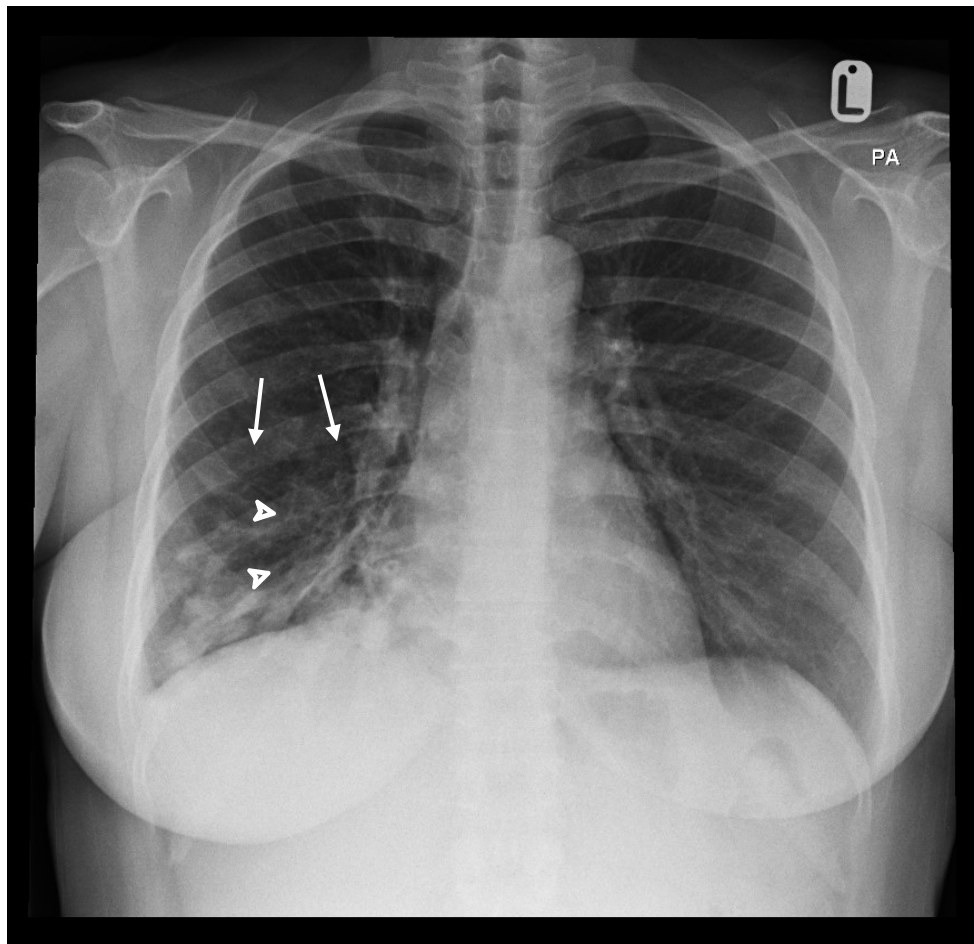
Frontal chest radiograph shows air space opacities at right middle and lower zones with obliteration of right cardiac border in keeping with consolidation. The right transverse fissure is retracted inferiorly (arrow) suggestive of right middle lobe collapse. Bronchiectasis is noted at right lower zone (arrowhead).
